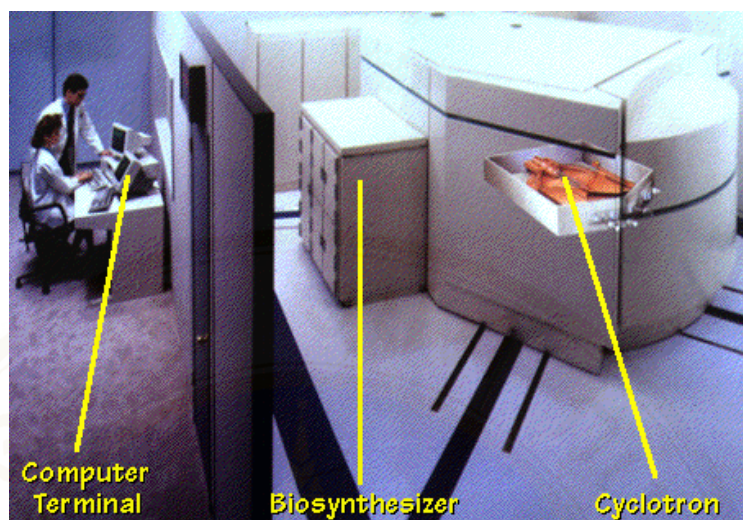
Production of F18-FDG in work area.
